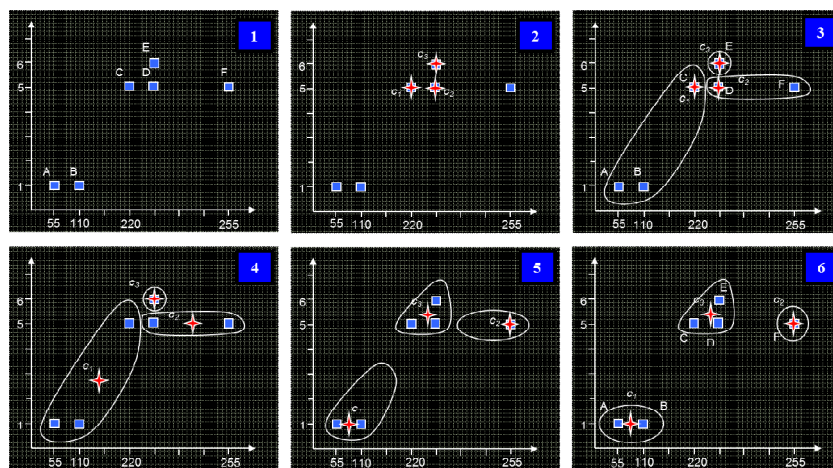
Applying the K-means clustering for MR image containing tumor.
